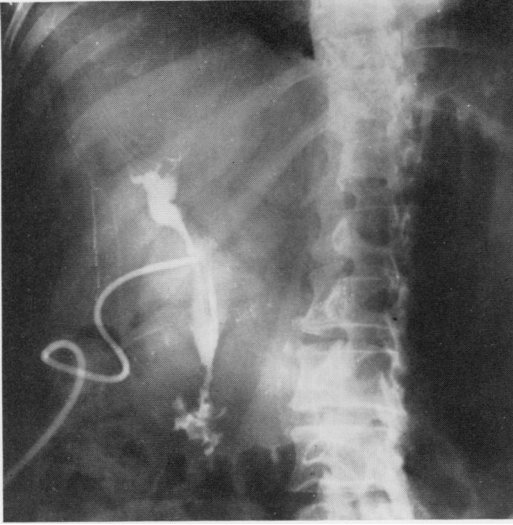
A postoperative x-ray cholangiogram in which there is a questionable filling defect in the distal common duct. Cinefluorographically, this defect was only seen intermittently and interpreted as action of the sphincter of Oddi in combination with duodenal peristalsis.
